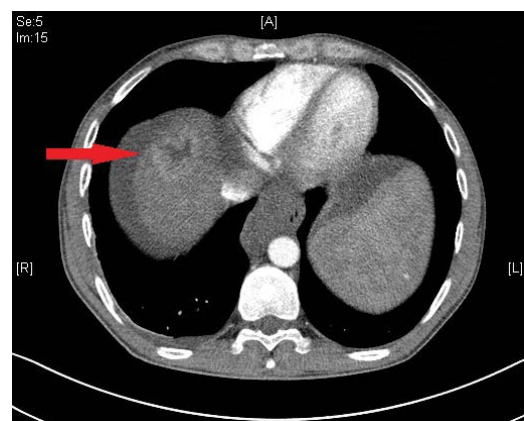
CT scan (arterial phase) with suspicious mass in liver segment VIII (the day before TACE).
